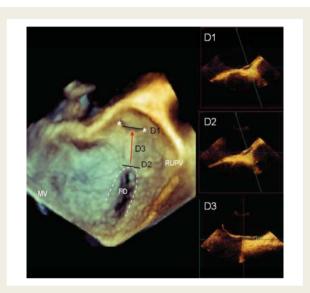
Dimensions of a patent foramen ovale. Threedimensional transoesophageal echocardiography image using 3D QLab software, Philips Healthcare (right panel, D1-3). D1, opening of patent foramen ovale into the left atrium, 10 mm. D2, opening of the patent foramen ovale at the right atrium aspect, situated at the superior aspect of fossa ovalis, 9 mm. D3, length of the tunnel of the PFO, 11 mm. the fossa ovalis as a percentage of the entire atrial septum. The purpose is to create an understanding of the fragility of the septum when placing a device and hence the risk of device displacement, i.e. the amount of available 'rims' to securely anchor the device. This information helps decide on the size of device to use.
